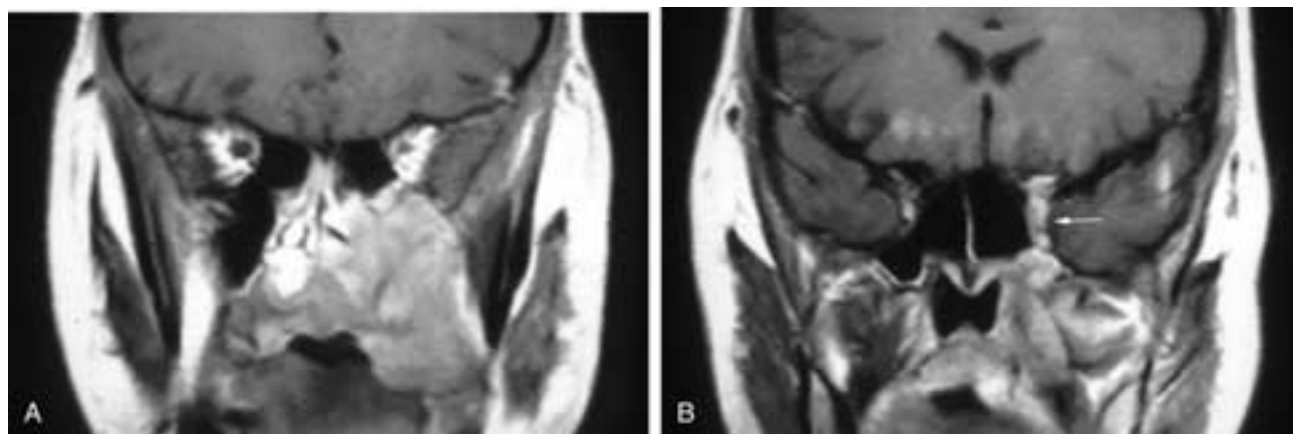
Coronal T1-weighted, fat-suppressed, contrast-enhanced MR ventral (A) and dorsal (B) images show a large mass in the left antrum, lower nasal fossa, and hard palate. The tumor has extended back through the pterygopalatine fossa and invades the left cavernous sinus (*arrow*). This patient had an adenoidcystic carcinoma.
